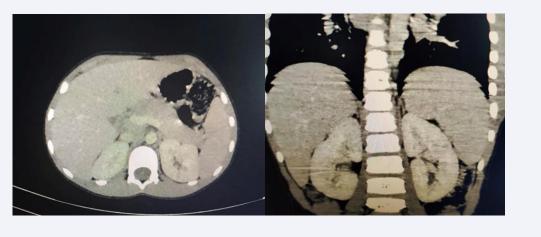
CT scan images showing significant hepatosplenomegaly.
